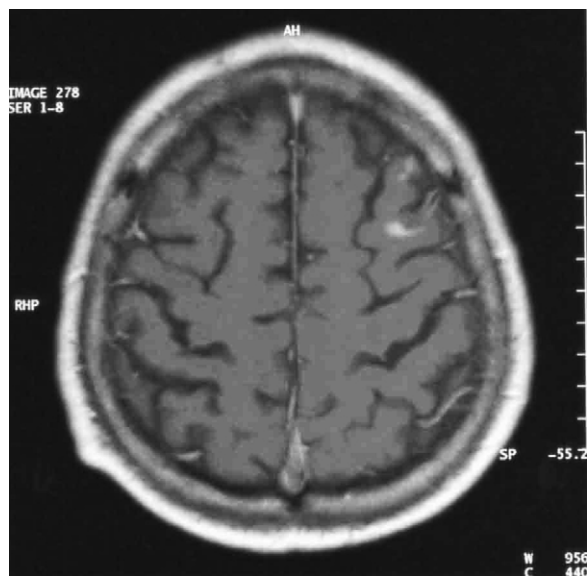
Contrast-enhanced T1-MRI in the patient 8 days after surgery with a blood brain barrier disruption in the same localization.
